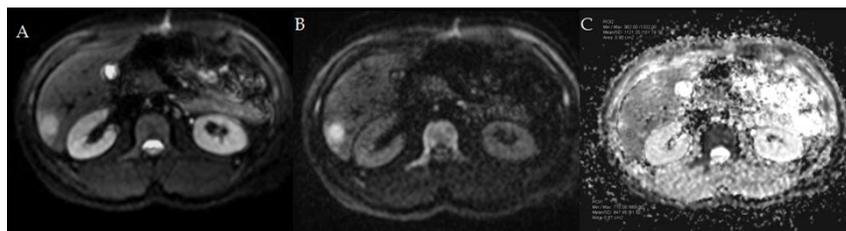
A 38-year-old man with colonic carcinoma; on a post-operative follow-up examination, he developed a liver lesion (ADC value was $0.847 \times 10^{-3} \text{mm}^2/\text{s}$), which is confirmed to be CRLM. (A and B) hyper-intense lesion on DWI at b value 50 and 800 respectively, (C) hypo-intense lesion on ADC map in comparison with liver background
